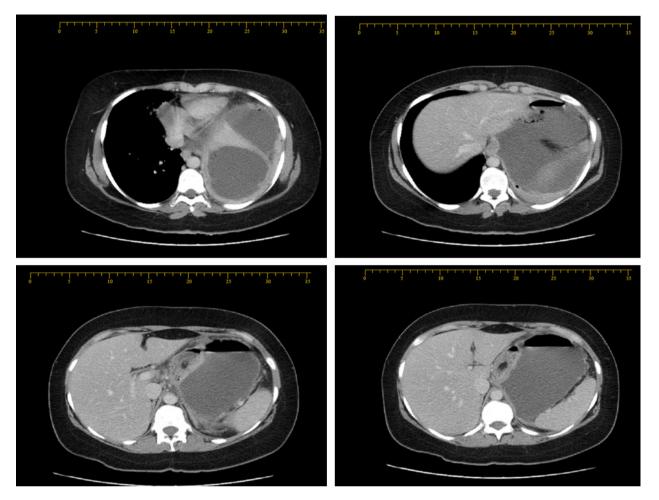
CT scan, abdomen view, showing the large left subphrenic abscess collection.
